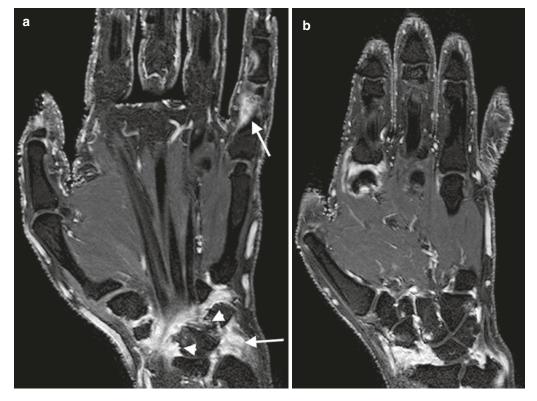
MRI in patient with scleroderma (\mathbf{a} , \mathbf{b}) Cor T1FS PG images with active synovitis at the (*arrows*) wrist and second and fifth MCPJs with early carpal erosions (*arrowheads*)
